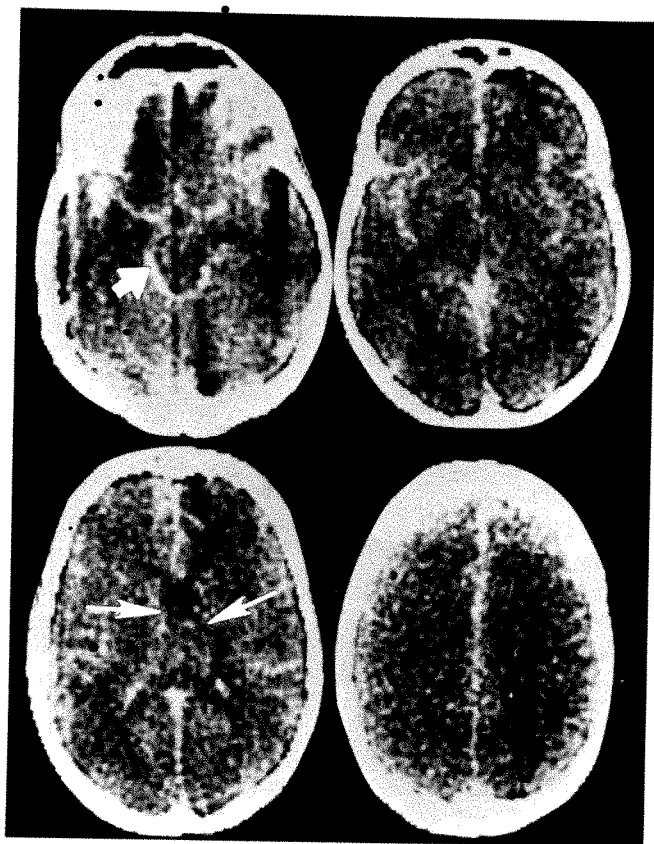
Case 1: subarachnoid hemorrhage with edema. CT scan on day of onset showing bilateral swelling with compression of ventricles (arrows). Note subarachnoid hemorrhage (arrowhead). Aneurysm not identifiable.
